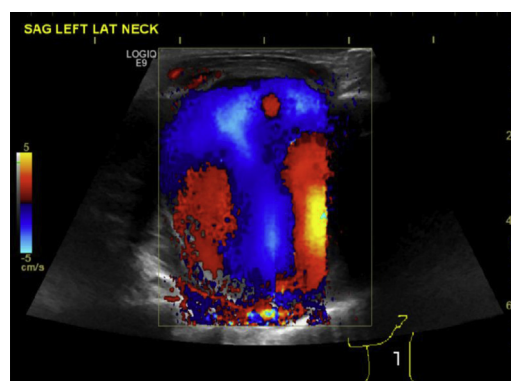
Ultrasound of the left neck demonstrating a pseudoaneurysm measuring 5.4 cm in the greatest diameter, with the “yin-yang” sign, which indicates bidirectional flow due to swirling within the false and true lumens of the pseudoaneurysm.
